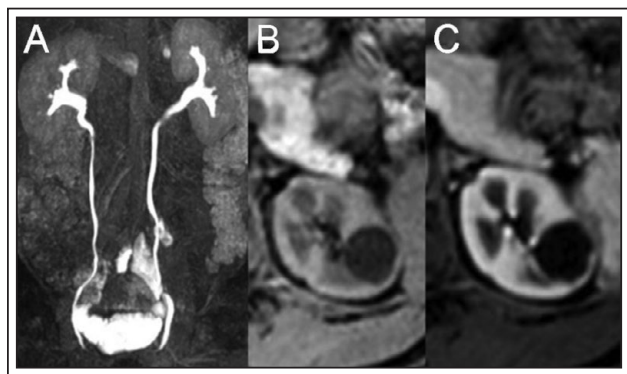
A) MRI urography showing lack of contrast filling of the renal cyst. Axial T1wi pre (B) and (C) post-contrast injection, showing the cystic lesion.
